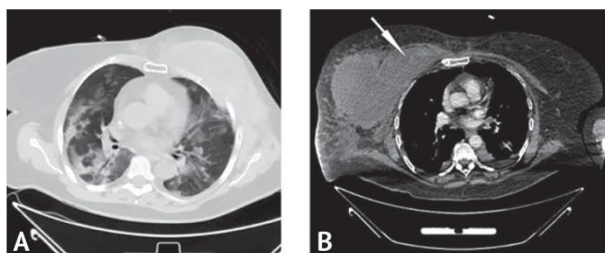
Computed tomography of the chest. A — axial projection in the lung window, pulmonary lesion of viral etiology up to 75% — CT-3, hematoma of the chest wall on the left; B — axial projection in the soft tissue window, chest hematoma on the right with signs of extravasation
